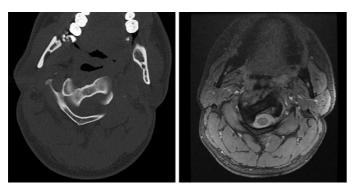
(Left) Axial computed tomography and (Right) Axial magnetic resonance imaging display bilateral rotatory deformity/dislocation of the axis on a normally positioned atlas
